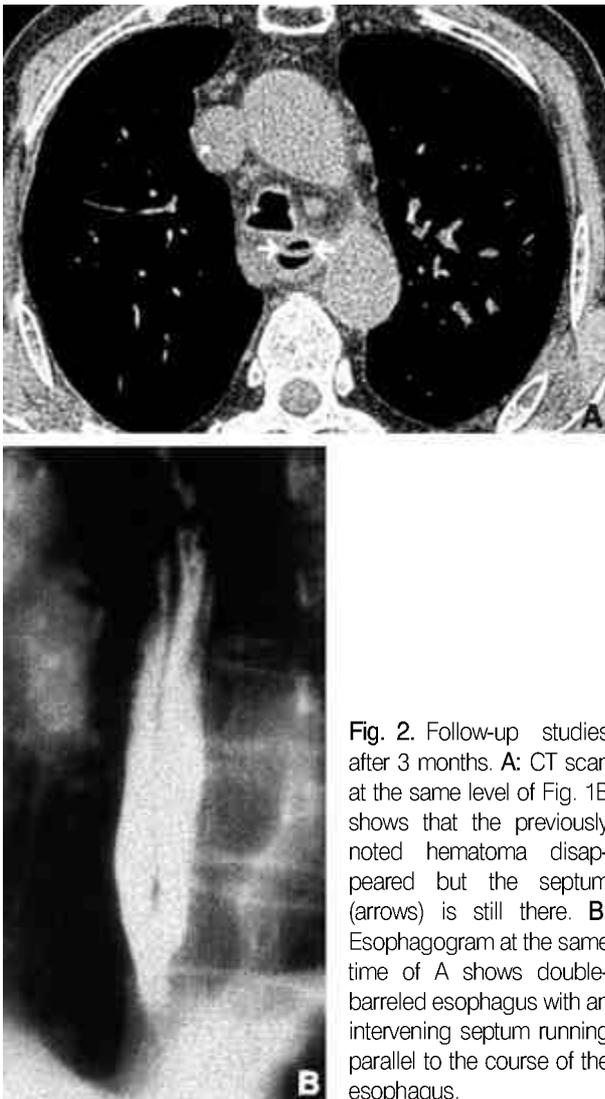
Follow-up studies after 3 months. A: CT scan at the same level of Fig. 1B shows that the previously noted hematoma disappeared but the septum (arrows) is still there. B: Esophagogram at the same time of A shows double-barreled esophagus with an intervening septum running parallel to the course of the esophagus.
